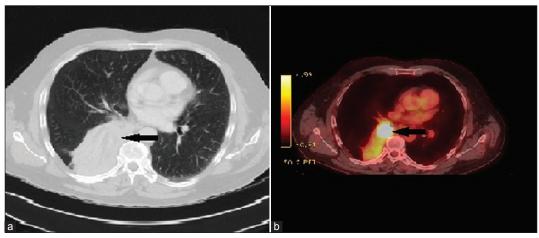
(a) CT Thorax showing right lower lobe lung carcinoma with post obstructive atelectasis (arrow); (b) Corresponding PET-CT showing the increased activity in the same area (arrow)
